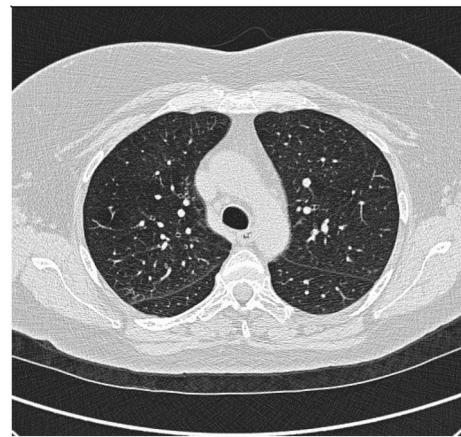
CT scan of lungs after removal of silicone breast implants.
